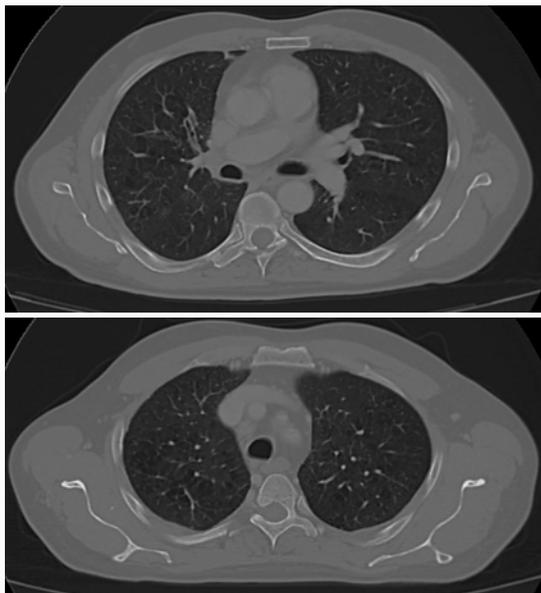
3rd restaging with CT scan on March 2015.
